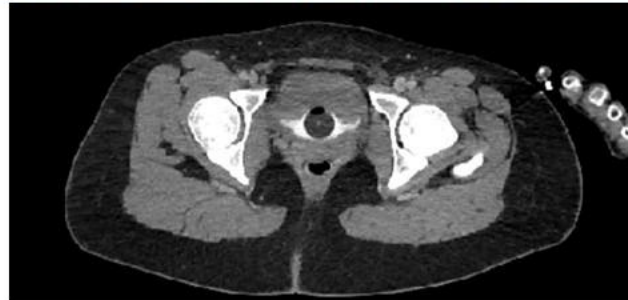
Axial CT with urine flow in to catheterized bladder contrasted posterior to free fluid
